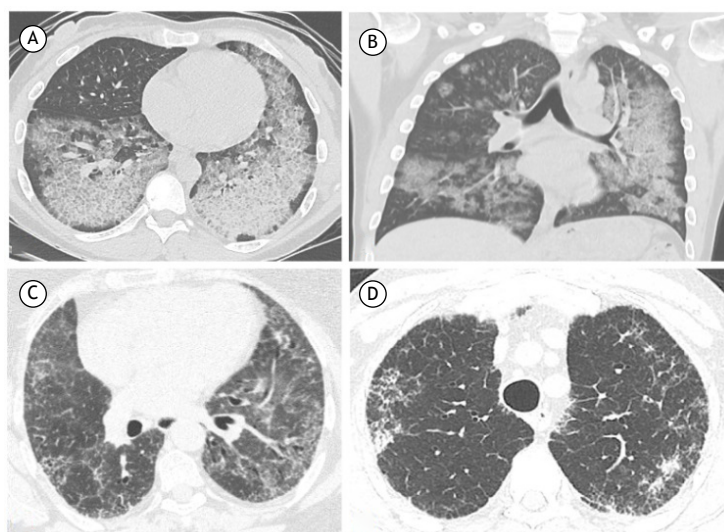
In A and B, chest CT showing ground-glass opacities and thickened interlobular septa, consistent with pulmonary alveolar proteinosis, in a patient using everolimus after kidney transplantation. In C, CT scan showing pulmonary ground-glass opacities, predominantly in the lower lobes, with traction bronchiolectasis in a 65-year-old female patient with RA after receiving methotrexate. In D, axial CT scan showing reticulated infiltrate and bilateral consolidations, predominantly in the upper lobes, in a male patient who received nitrofurantoin.
